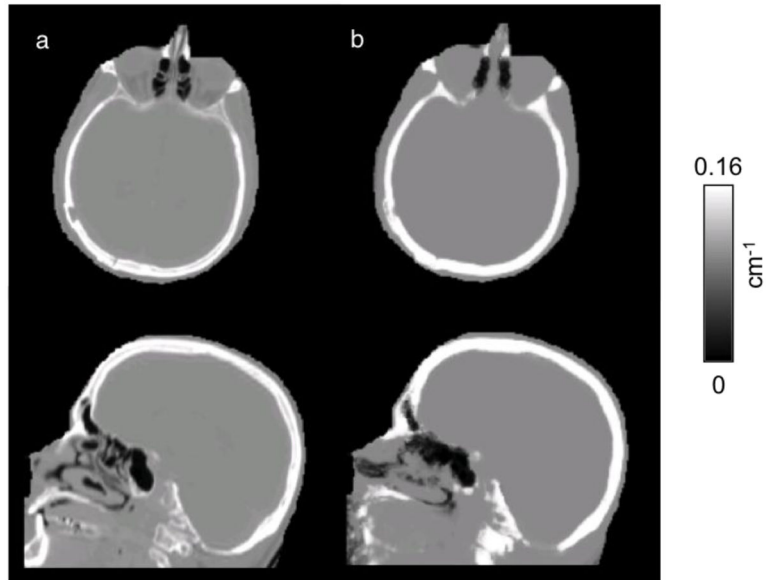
Representative μ -maps, in the sagittal and transverse orientations, derived from the scaled CT method (a) and the PAC-map generation method (b)
